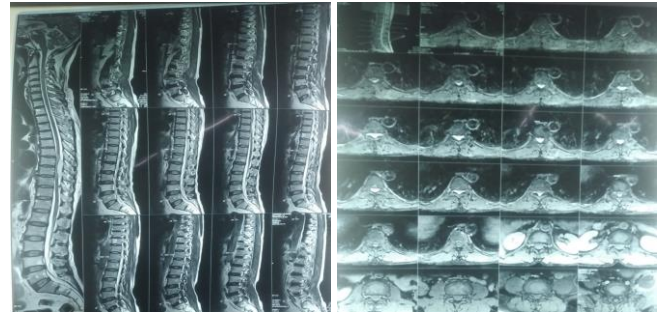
MRI images tumor extending from D7 to D 10 vertebrae levels
